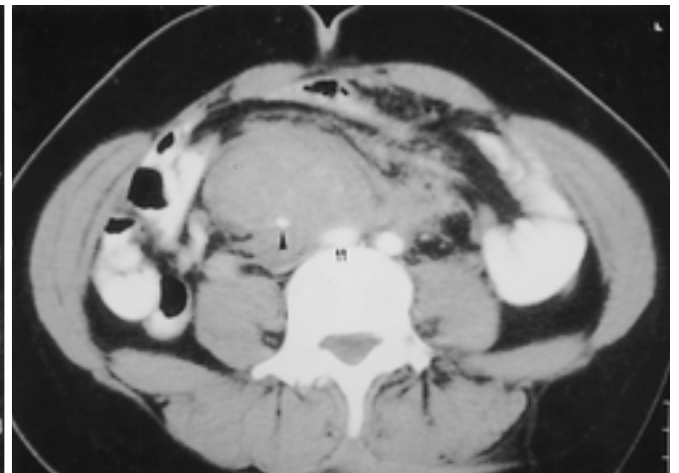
24 months after operation, follow-up CT scan shows previous lesion is slightly progressed (double arrow), and confined but is not still definite.
